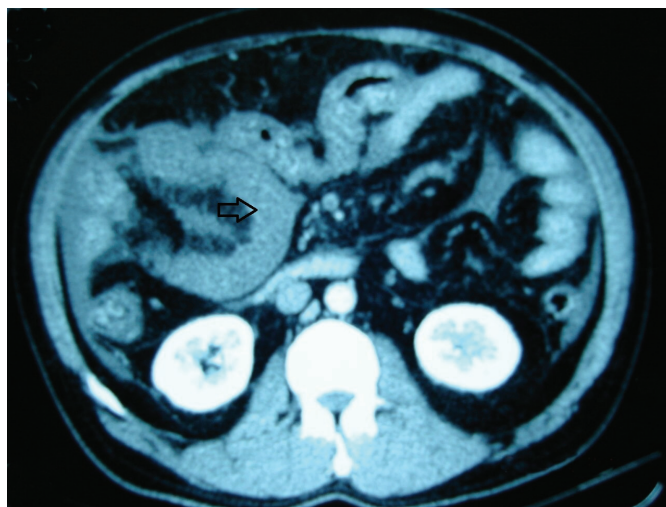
Abdominal computed tomography scan with injection showing a thickened ileal loop with infiltration of its mesentery and peritoneal effusion.
